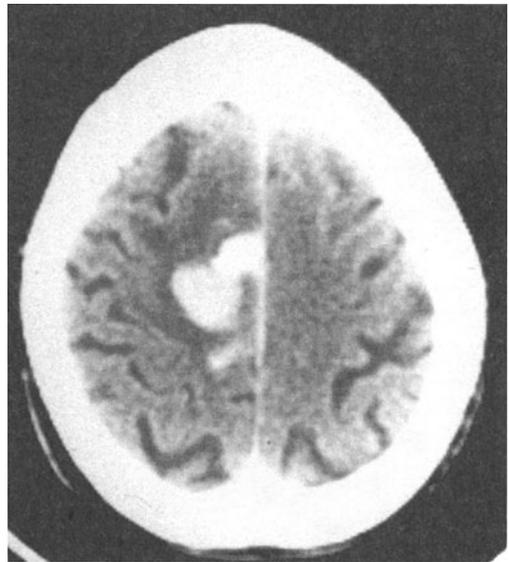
CT scan. Cerebral hemorrhage in a 90-year-old man with left sided weakness primarily involving the right leg and shoulder. See case 2-1 at end of this chapter.
